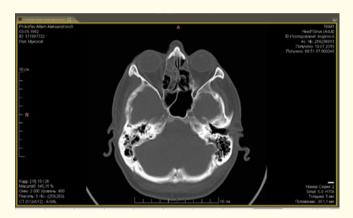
Computed tomography of the brain from 10.07.2019, before the operation to the patient.
